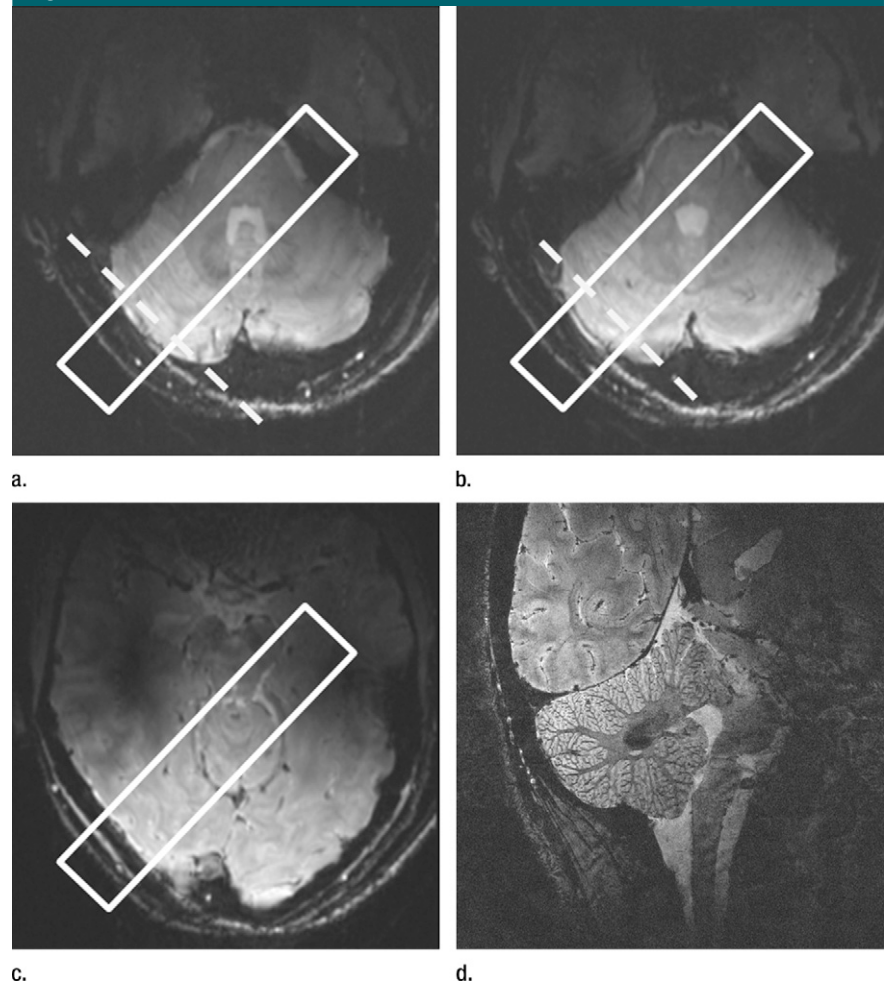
(a–c) MR images in 28-year-old male volunteer. Transverse low-spatial-resolution multislice gradient-echo images (repetition time msec/echo time msec, 200/5) acquired with 0.6-mm in-plane resolution and 1-mm section thickness were used as anatomic references and to plan the acquisition of subsequent higher-resolution images. Dashed white lines on a and b indicate estimated main cortical direction and are used to position image volume, represented by white rectangles. (d) Representative full-field-of-view high-resolution magnitude gradient-echo image shows from where the anatomic details shown in the subsequent images were highlighted.
